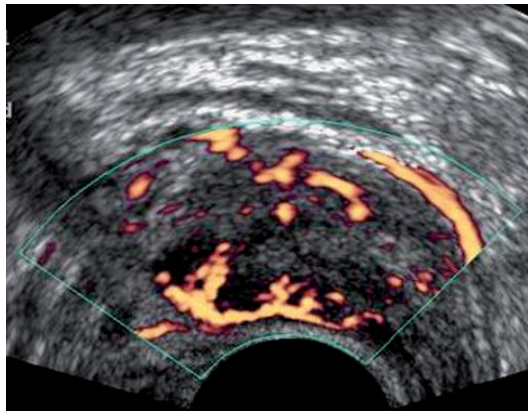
Power Doppler. Prostate. Transrectal approach, axial scan. The image depicts the vasculature of the gland, which is more evident peripherally
